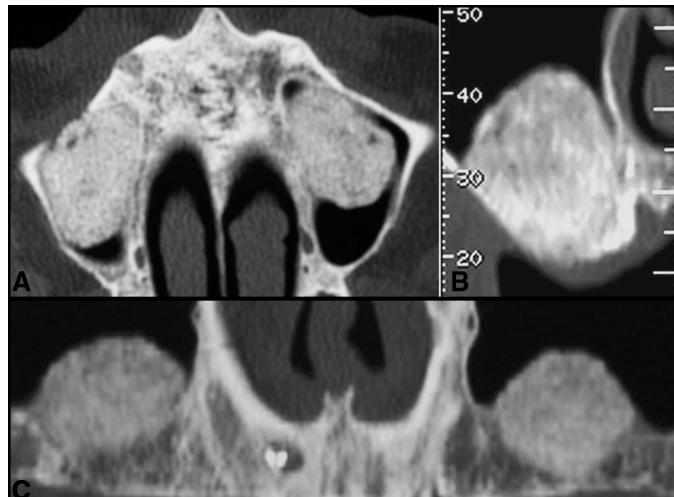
A and B, 10 days postsurgical x-ray scan of a bilateral sinus-lift. The graft appears homogeneous with metronidazole (A) but nonhomogeneous without metronidazole (B). C, After 2 months, the sinus treated with metronidazole appears homogeneous and dense, whereas the graft without metronidazole shows the nonhomogeneous areas generally described (practitioner 1).
